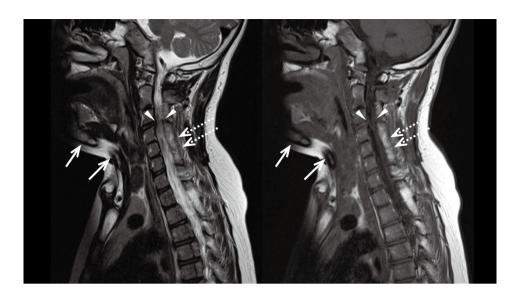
A magnetic resonance image shows tubular heterotopic ossification extending downward from the inferior border of the mandible to the jugular notch (arrow), fusion of facet joints at the C4/C5 and C5/C6 levels (open arrow), and central canal stenosis at the C3/4 level (arrowhead).
